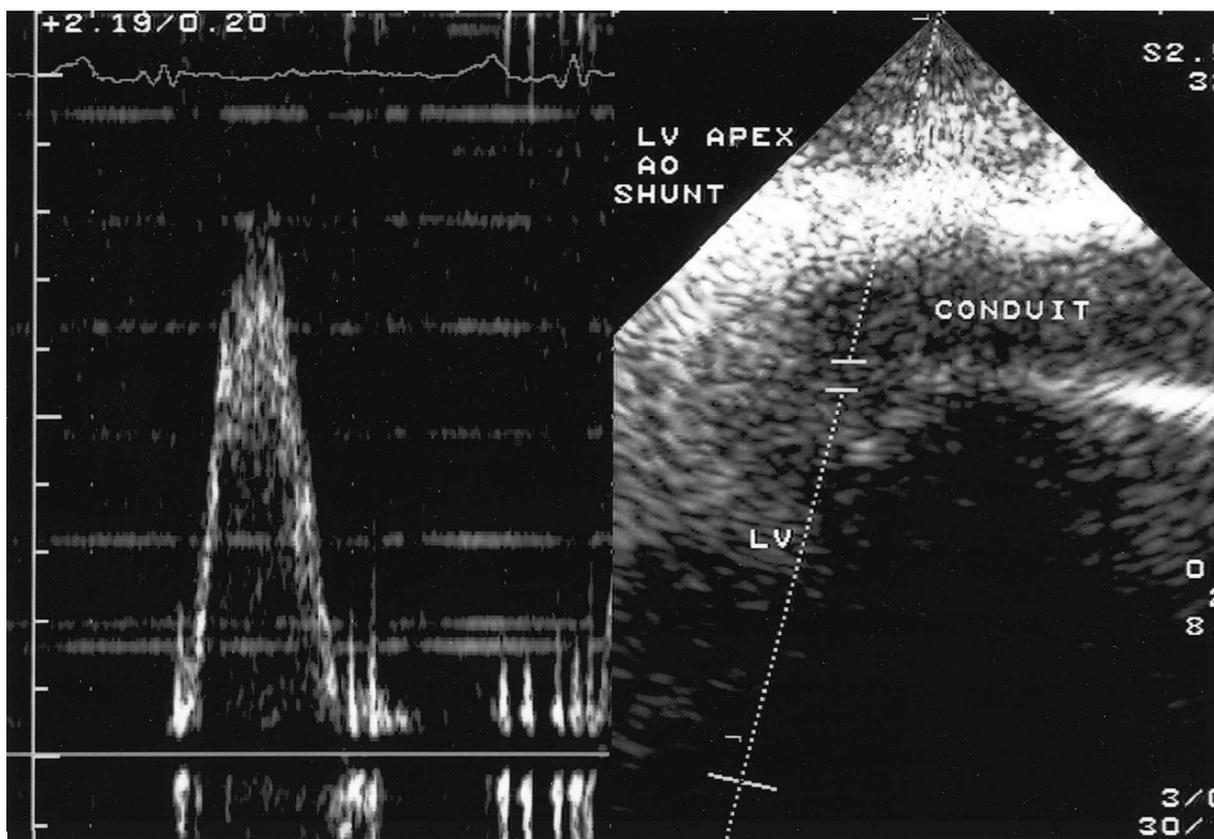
TTE image with pulsed-wave Doppler from the apex demonstrates laminar conduit flow near the LV-conduit junction. TTE = transthoracic echocardiography; LV = left ventricle.
